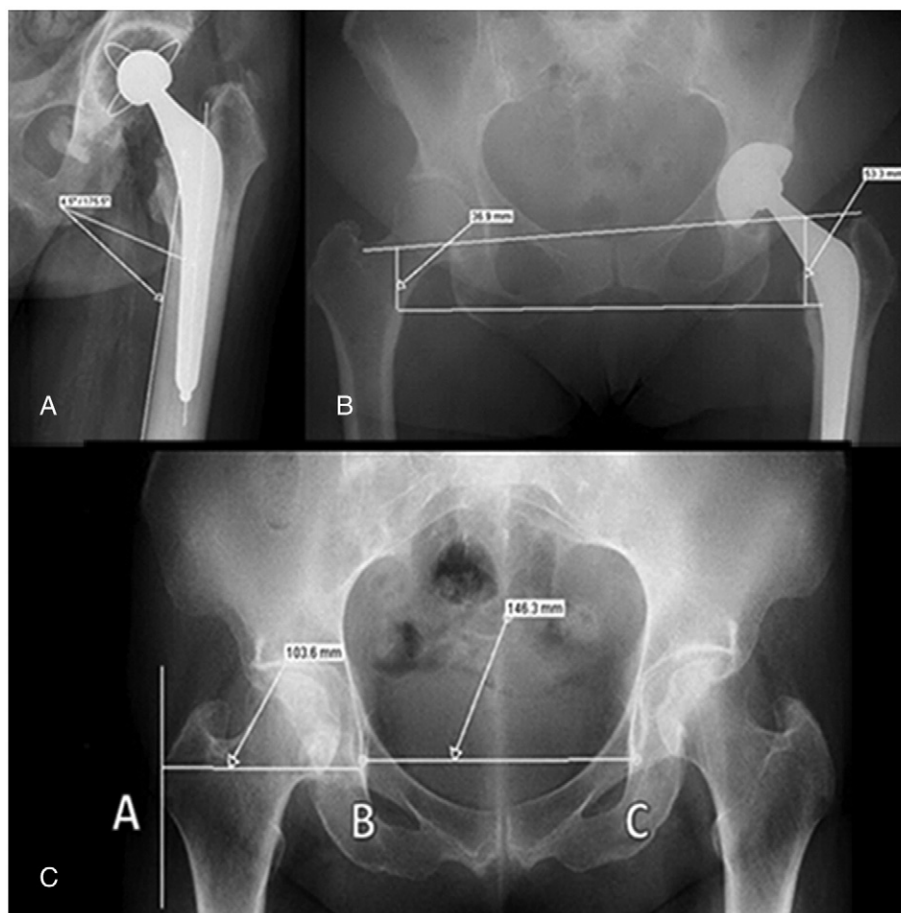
Radiographic measurements. (A) Screening for valgus or varus malposition greater than 2° . (B) Measurement of femoral length discrepancy. (C) Measurement of femoral offset.
